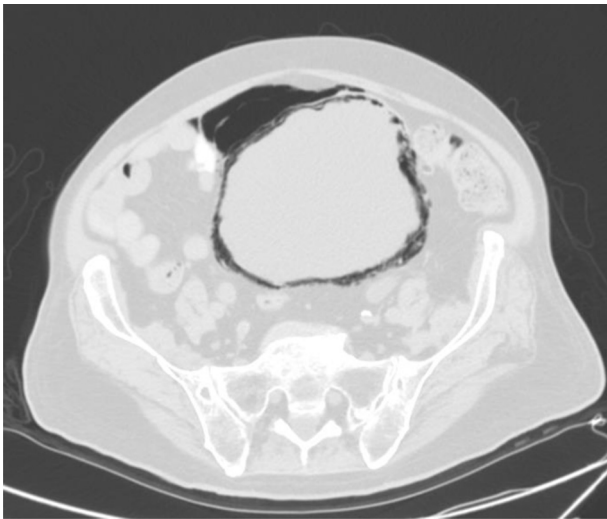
CT scan of the pelvis in axial view (lung window): diffuse air infiltration within the bladder wall.
